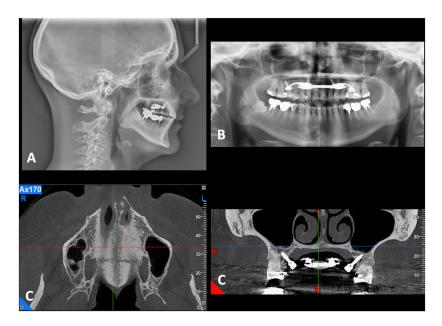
Posttreatment records. A, Lateral radiograph; B, Panoramic radiograph; C, CBCT axial slices.
